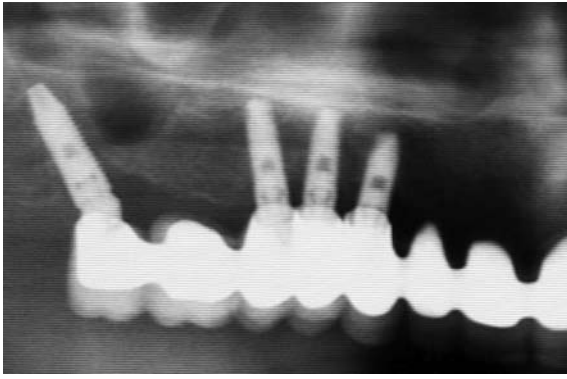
Intraoral radiograph of unilaterally edentulous patient with pterygomaxillary implant after 5 years of loading
